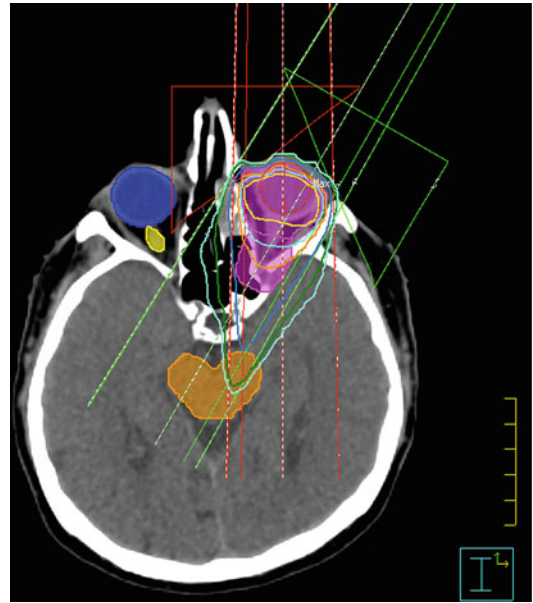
Axial CT with “wedged pair” photon beam demonstrating coverage of the planning target volume (PTV) covered by the 95 % isodose line
